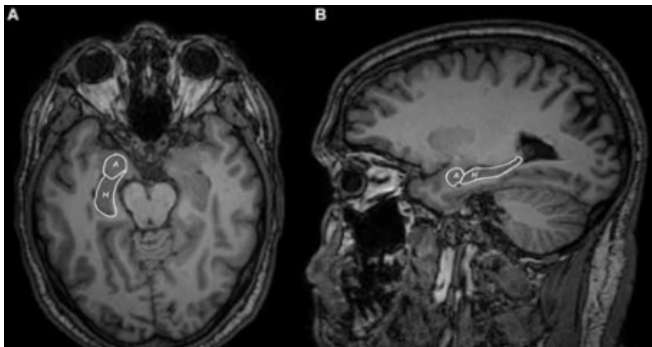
Axial (A), sagittal (B) MRI views of hippocampus (H) and amygdala (A) segmentation [15]. Brain regions that are affected earlier by AD
